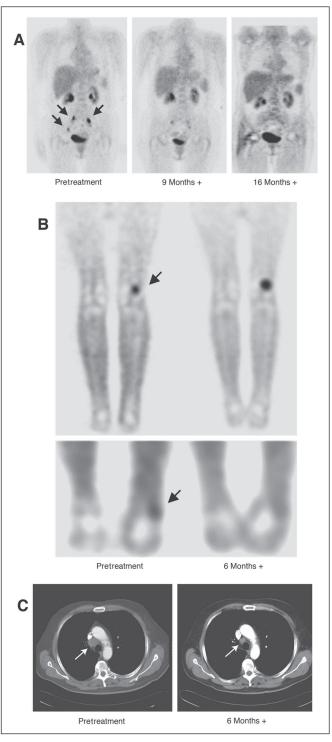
T-cell transfer-induced regression of metastatic disease. Positron emission tomography/computed tomography images showing (A) complete regression (CR) of abdominal lymph node (LN) metastases in patient 11; (B) CR of one subcutaneous metastasis at the left foot but progressive lesion at the left poplitea in patient 8; and (C) partial regression of a paratracheal LN metastasis in patient 5 after T-cell therapy.
